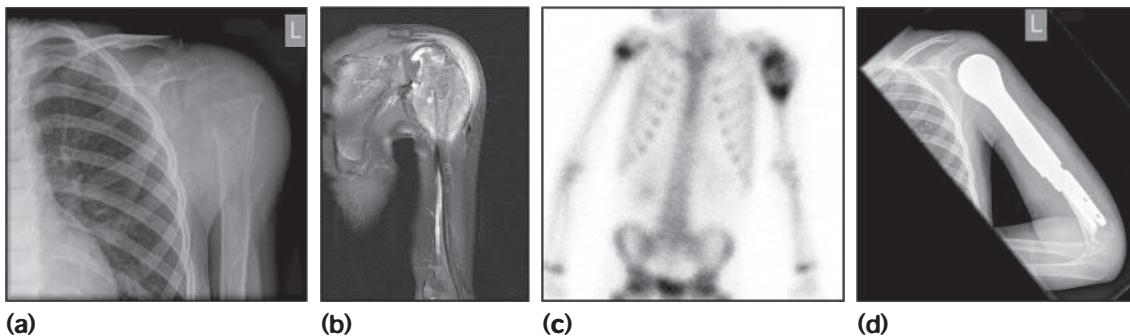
Ewing sarcoma of the humerus. (a) Plain X-ray shows a destructive bone lesion within the proximal humeral metaphysis; (b) MRI shows a large destructive soft tissue mass arising from the proximal metadiaphysis of the left humerus; (c) bone scan shows prominent abnormal tracer uptake in the proximal left humerus; and (d) post-surgery, most of the humerus has been resected and replaced by a metallic prosthesis.
